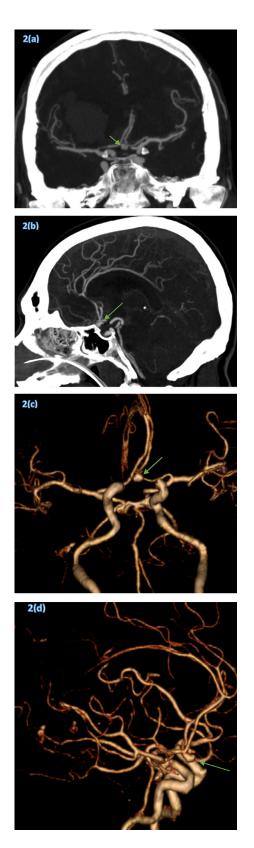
Computed Tomography Angiogram (CTA) of the brain in coronal view(a), coronal view (b), and 3D reconstruction [(c)&(d)] showing the saccular aneurysm of the anterior communicating artery.
